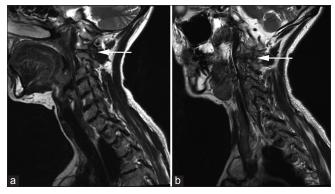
Right (a) and left (b) paramedian sagittal T2-weighted magnetic resonance imaging of the cervical spine. The exiting C2 nerve root is severely compressed on the left, in contrast to the right (white arrows)
